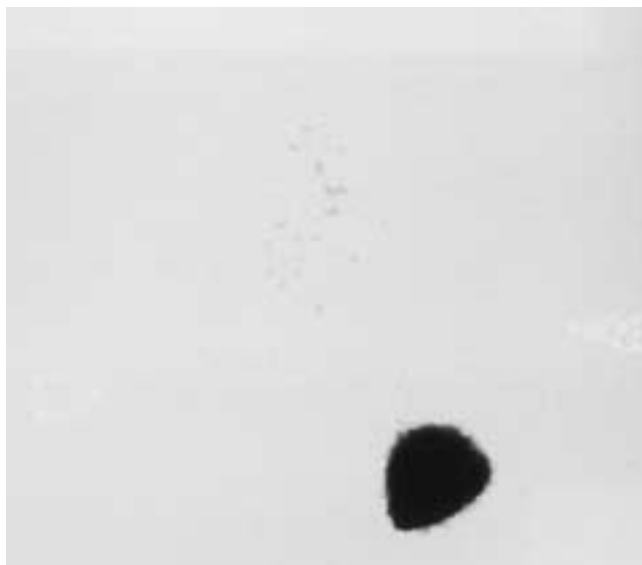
A 60-year-old woman presented with hyperthyroidism. The 24 hour uptake was 46% (upper limit of normal is 30%), and scintigraphy showed a hot nodule with suppression of the remainder of the gland consistent with an autonomous nodule. (Courtesy of Dr. Joseph Sam, Department of Radiology, Ultrasound Division, University of Pennsylvania Medical Center.)
